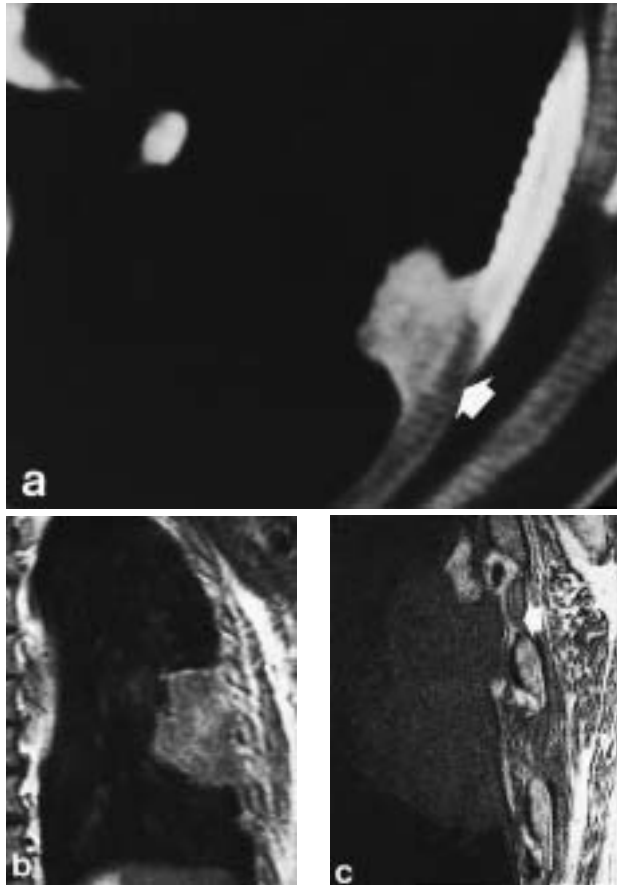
Malignant invasion of the chest wall. a) Computed tomography shows pleura-based tumour mass with broad contact to the intercostal soft tissue and presumable invasion (arrow). b) Conventional coronal T1-weighted magnetic resonance (MR) image demonstrates broad tumour contact with the lateral chest wall. c) High-resolution sagittal T1-weighted MR image excellently reveals focal invasion of the inner chest wall with disruption of the peripleural fat, involvement of the innermost intercostal muscle and the intercostal fat (arrow). Surgery confirmed focal chest wall invasion by malignant fibrous histiocytoma.
